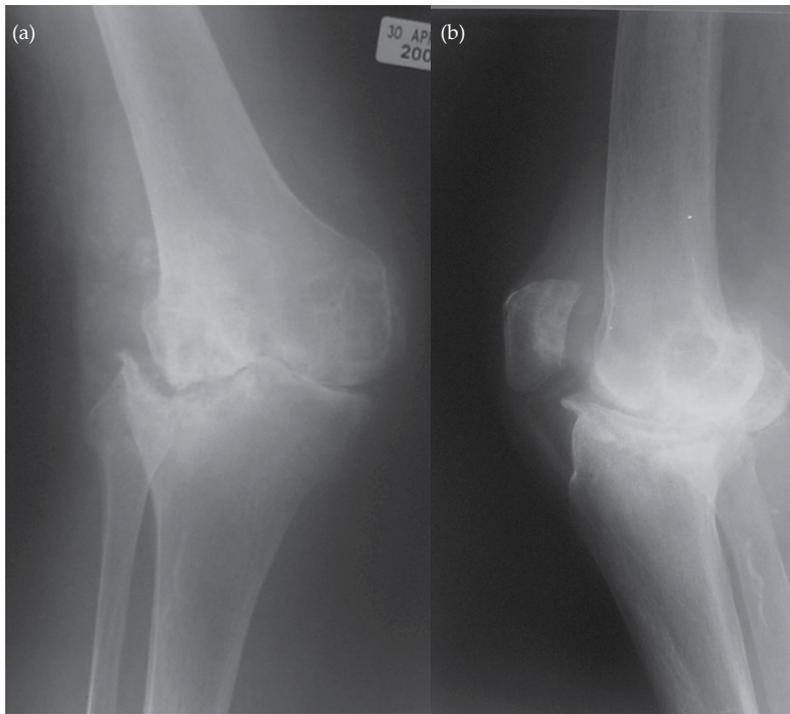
Plain anteroposterior (a) and lateral (b) radiographs of the knee in a patient with rheumatoid arthritis. Degenerative changes are present in all 3 joint compartments. There is collapse of the lateral compartment with resultant valgus deformity. Erosion of the anterior aspect of the distal femoral metaphysis due to pannus is also seen.
